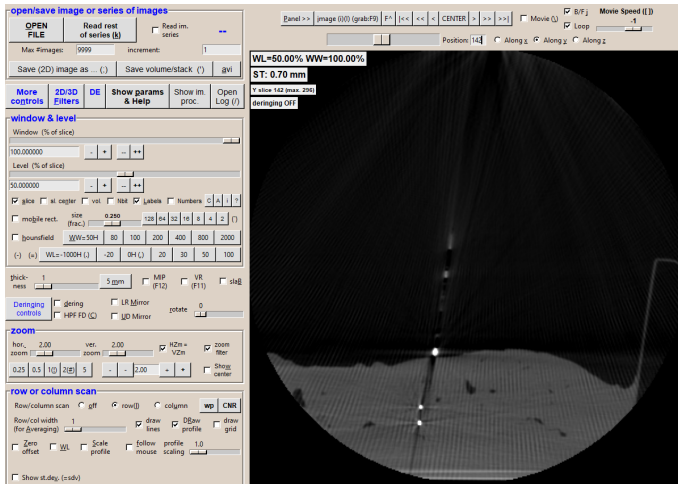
Preview of the CBCT image for T6 in the image viewer dView. The needle is the white dot coming into the liver, the middle white dot is the tumor marker and the lower white dot is the endovascular catheter marker. The needle path can be deduced from the image by looking at the needle direction; the extension of the path is pointed toward the endovascular marker.
